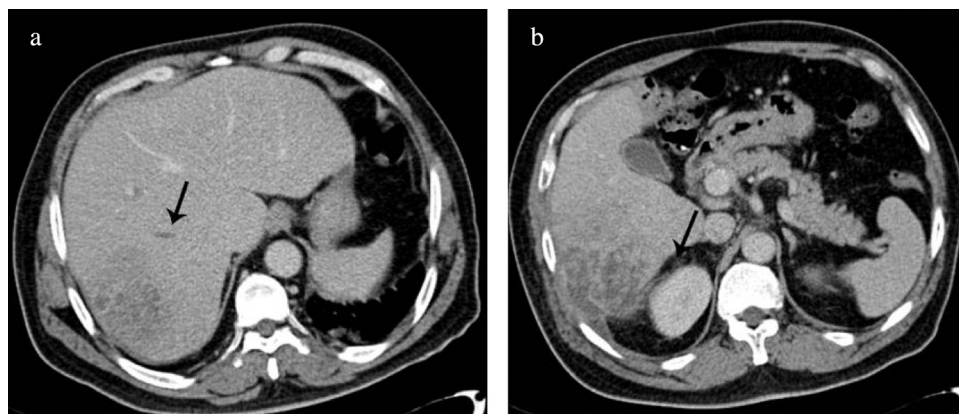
Images of a 61-year-old man who presented with fever and abdominal pain for 2 days. (a) Contrast-enhanced CT showed a multilocular abscess in the right lobe of the liver. Thrombophlebitis was shown by a hypodense filling defect (arrow) in the right hepatic vein. Abscess cultures were positive for *K. pneumoniae*. (b) CT showed a ruptured abscess characterized by blurred edges with a narrow strip of low density in subcapsular area, and exudation (arrow) in the fat gap between the liver and right kidney.
